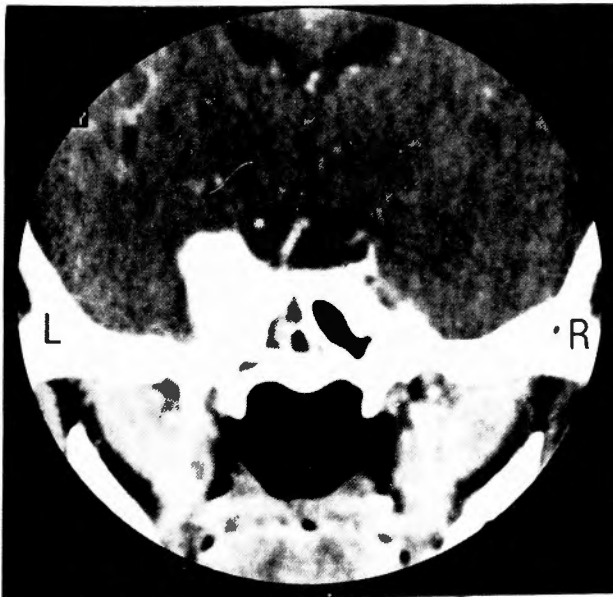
Patient 1.* Direct coronal computed tomogram after contrast medium injection, showing markedly enhanced left parasellar mass.
